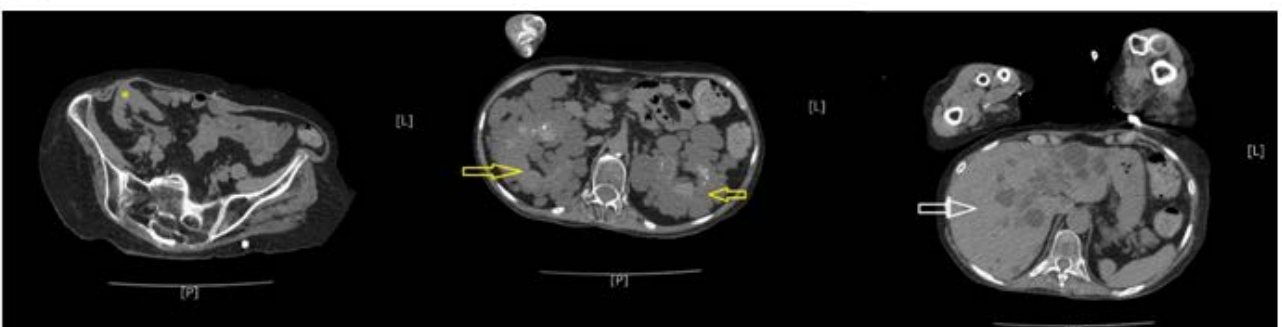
CT scan Abdomen and Pelvis without intravenous contrast (A and B) demonstrating bilateral polycystic kidneys (yellow arrows) and several cysts in the liver (white arrow). Transplanted kidney is also visualized (marked with *)
